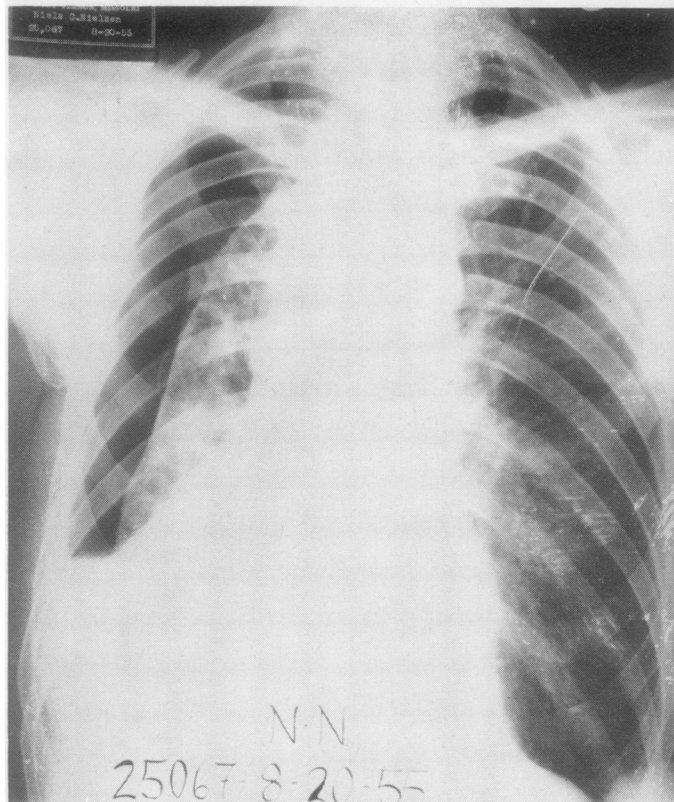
Chest radiograph shows 'destroyed lung' with empyema and bronchopleural fistula on the right.
